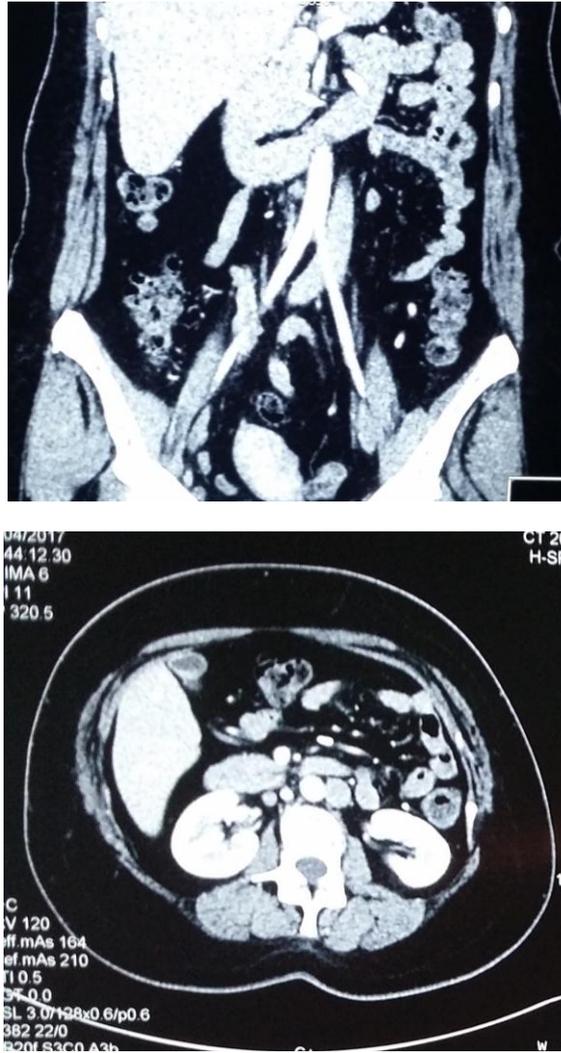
CT sections showing the inferior vena cava located to the left of the abdominal aorta.
